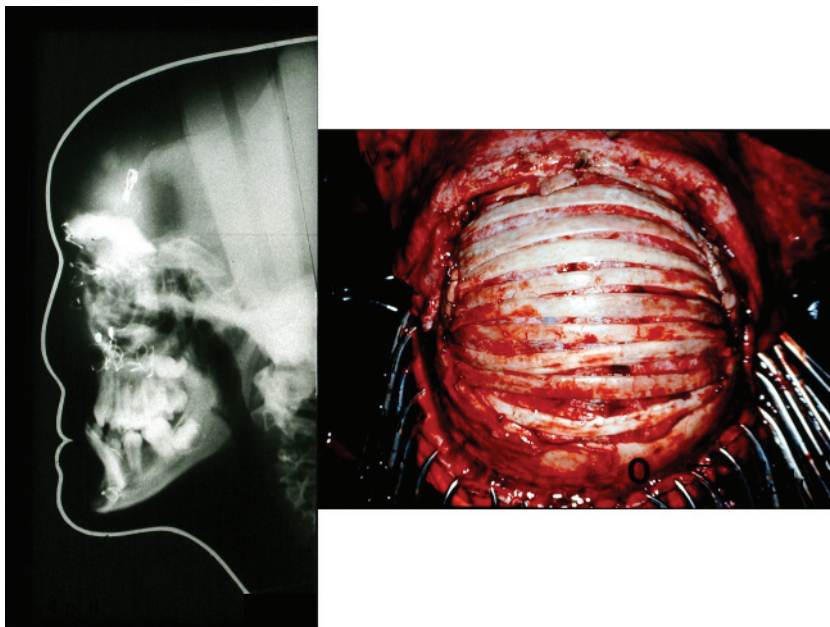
Patients lateral skull radiograph after removal of cranial plate due to infection plus view of reconstruction of skull defect with 14 half ribs.
